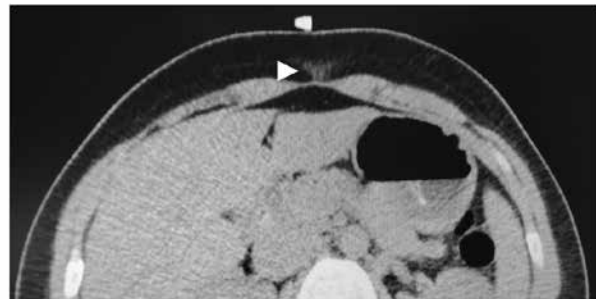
Preoperative CT scan. The figure shows the preoperative CT scan at the level of the lesion. The location of the lesion is identified by the white arrowhead.
